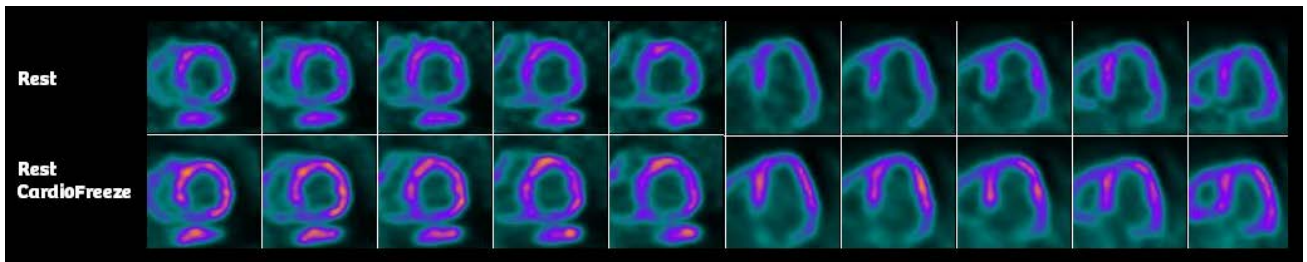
PET/CT myocardial viability study at rest shows a large infarct involving most of inferior wall and apex with thinned out but viable myocardium in the septum. Dilated left ventricular cavity with a low ejection fraction of 26% at rest suggests severe ventricular dysfunction.
